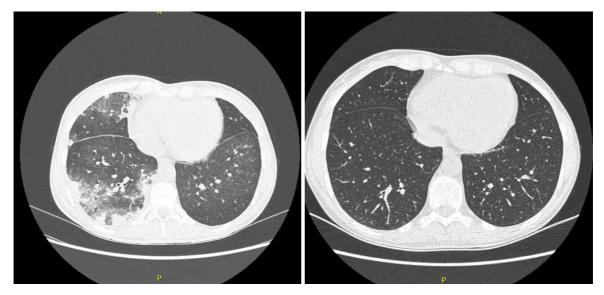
High-resolution computed tomography (HRCT) of the lungs of July 2020 (left) and January 2021 (right)
